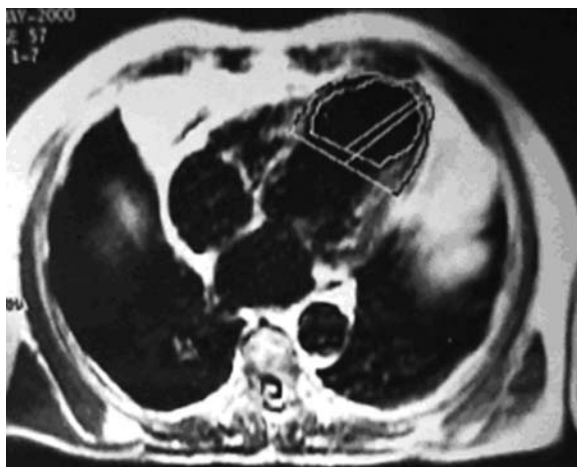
Four-chamber view, SE, T1-weighted sequence. Marked borders of the left ventricle aneurysm.
